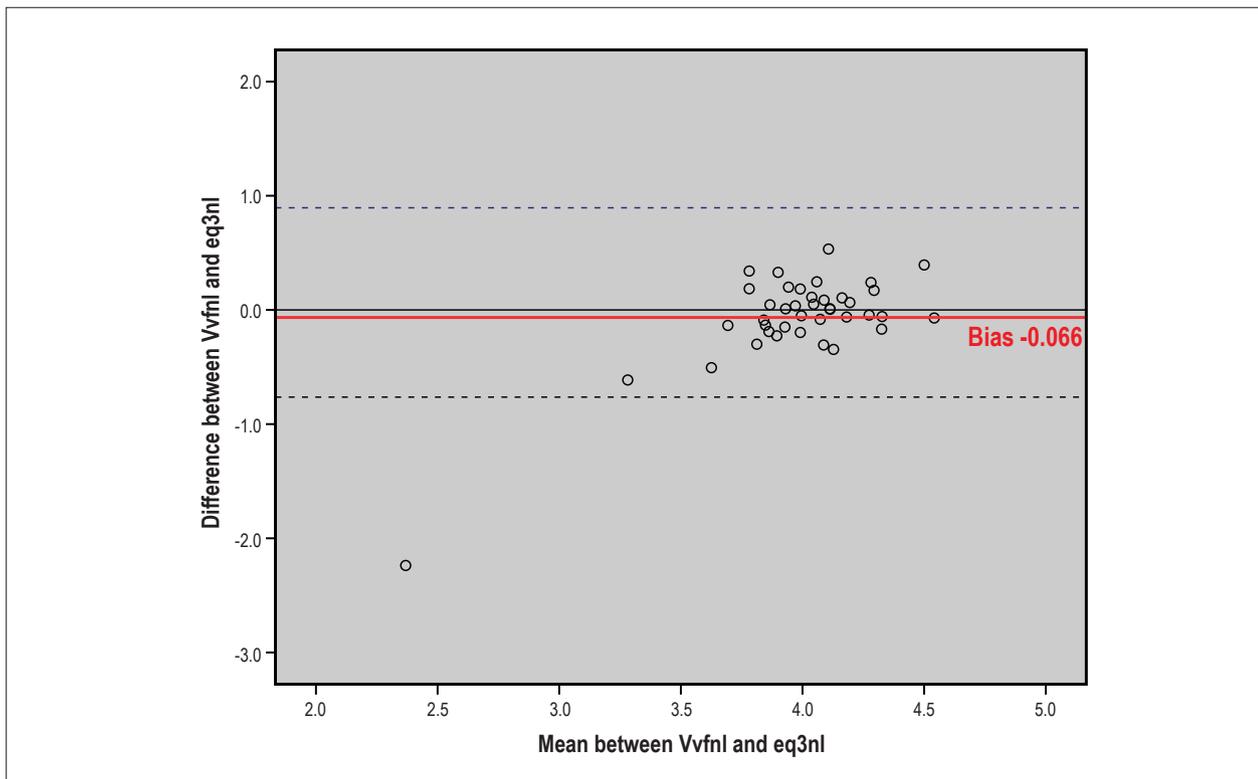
Agreement between ultrasound and the predictive equation of visceral fat assessed by the Bland Altman test; Vvfnl - volume of visceral fat natural logarithm evaluated by ultrasonography; eq3nl - natural logarithm of the volume of visceral fat estimated by predictive equation
